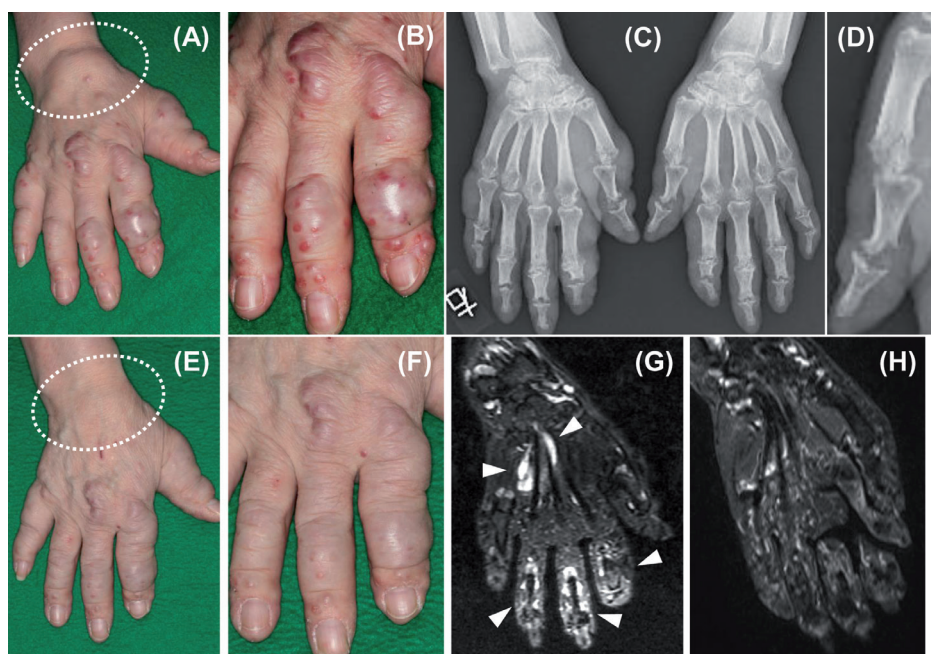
(A, B, E, F) Clinical photographs of the right hand. (A, B) Before treatment with adalimumab. Multiple papules and subcutaneous nodules are visible on all fingers, and swelling of the right wrist (dotted circle). (E, F) Ten months after starting adalimumab. Multiple nodules of fingers significantly decreased, and swelling of the right wrist disappeared. (C, D, G, H) Imaging of the hands. (C, D) Plane X-ray of the hands. Progressive erosions with pencil-in-cup deformities, spur formations and subluxations of the distal and proximal interphalangeal joints and metacarpal phalangeal joints of all fingers (D: High magnification image of bones in left thumb). (G, H) Magnetic resonance (MRI) with short-tau inversion recovery (STIR) of the right hand. (G) Before treatment with adalimumab. High signal intensities in tendons of the flexor palmar and digital muscles. (H) Ten months after starting adalimumab. High signal intensities in the tendons of the flexor palmar and digital muscles had disappeared.
